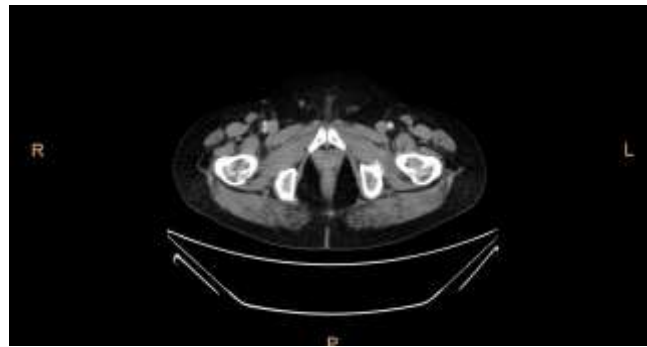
Case 1, plain pelvic CT (contrast-enhanced), axial section at the level of the femoral heads. Patient identifiers, hospital name, and scan date/time have been cropped from the image; orientation markers (R, L, P) are retained. The gland region shows no discretely margined soft-tissue mass, despite the DRE and PSA findings described in Section 3.9.2, consistent with CT's limited soft-tissue contrast (Section 3.1).
